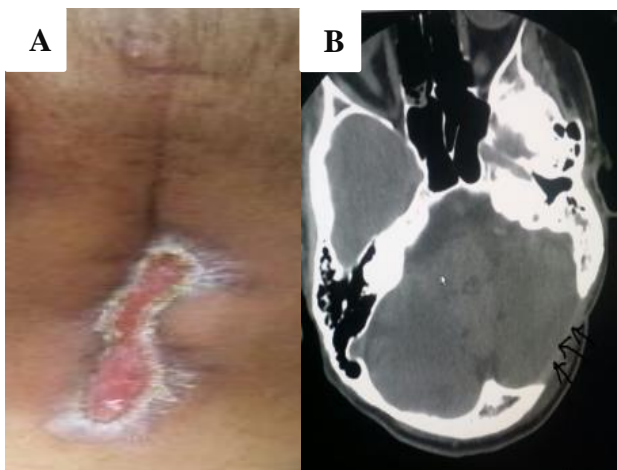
(A) Almost healed wound, sutures removed. (B) A plain CT of the head with complete recovery, the site of craniotomy shown also (arrows).
